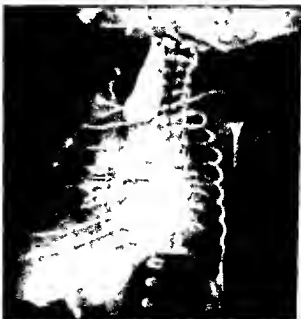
Esophageal atresia with distal fistula. A, radiograph with patient erect in which the proximal pouch is outlined by use of a catheter and small amount of barium (even less could be used). B, frontal and C, lateral projections show a rare unusually long pouch which facilitates repair.
